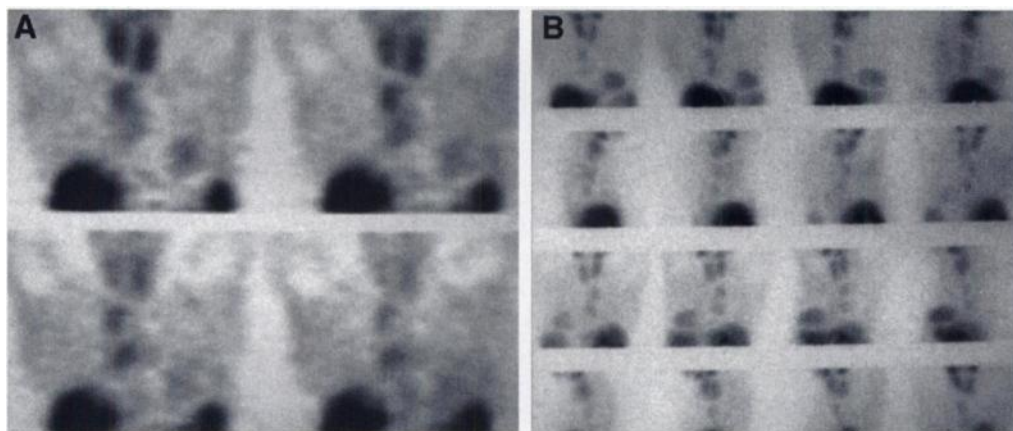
(A) Four coronal SPECT slices that show ^{99m}Tc -tetrofosmin uptake in posterior mediastinum, according to lymphadenopathy, due to sarcoidosis Stage I. (B) Three-dimensional imaging (from anterior over right lateral, posterior, left lateral to anterior position) clearly demonstrates the ^{99m}Tc uptake in the posterior part of the mediastinum. Additional uptake in the thyroid, heart and liver is also shown. This image also shows no pathologic ^{99m}Tc -tetrofosmin uptake in the left breast.
